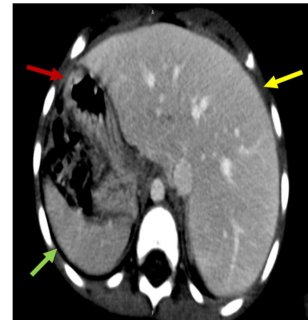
Abdominal CT in axial section, at the height of the hypochondria, with injection of the PDC, in the portal phase showing the liver on the left (yellow arrow), the spleen (green arrow) and the stomach (red arrow) on the right.
